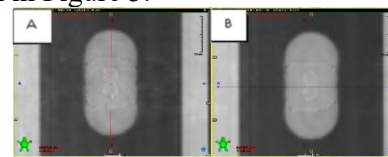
A) The default protocol and B) the modified protocol were used to acquire 4D-CBCT images of a moving target with a period of 6 seconds and 30 cm amplitude.
